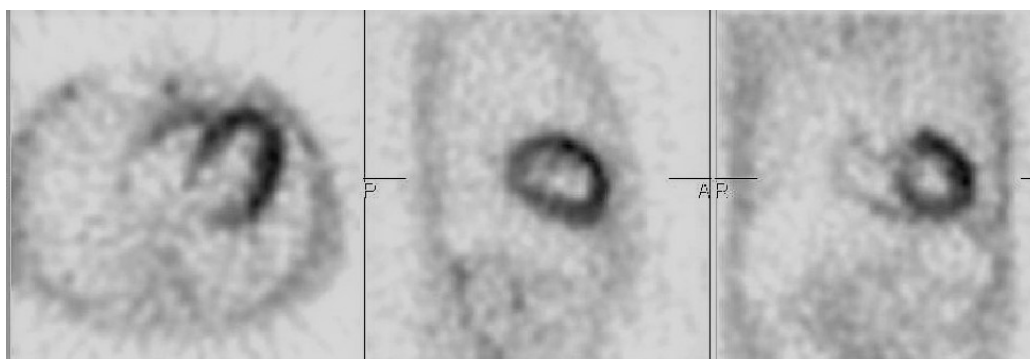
Single photon emission computed tomography reconstruction along the transverse, sagittal, and coronal axes with evident increased fixation of radiopharmaceuticals in the myocardium.
